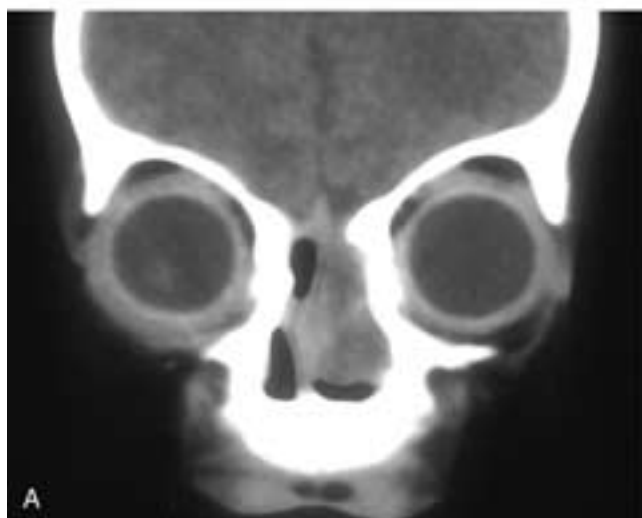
Coronal CT scan (A) and T1-weighted, fat-suppressed, contrast-enhanced MR image (B) on a newborn show a cystic, expansile mass in the left nasal cavity. No intracranial communication was demonstrated. The central floor of the anterior cranial fossa was intact. This region is not yet ossified in the newborn. This patient has a nasal glioma.
